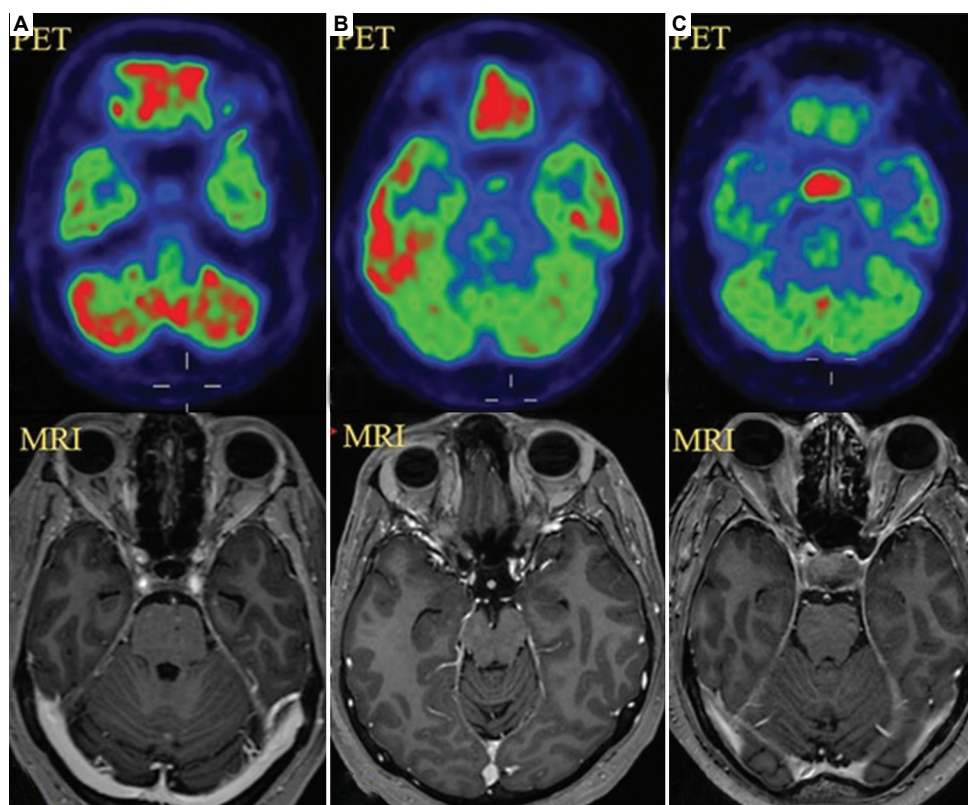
Grades of pituitary uptake ^{18}F -FDG PET/CT. (A) Low uptake in a 40-year-old female with breast cancer on hormonal therapy; PET/CT and MRI show a normal pituitary gland. (B) Intermediate uptake in a 35-year-old female with choriocarcinoma and lung metastases; PET/CT and MRI show a normal pituitary gland. (C) High uptake in a 64-year-old male with colon cancer; PET/CT shows increased pituitary activity, with MRI confirming a pituitary macroadenoma. This figure is adapted from Jain *et al.*,² available under a Creative Commons Attribution (CC BY 4.0) license. Abbreviations: CT: Computed tomography; MRI: Magnetic resonance imaging; PET: Positron emission tomography.
